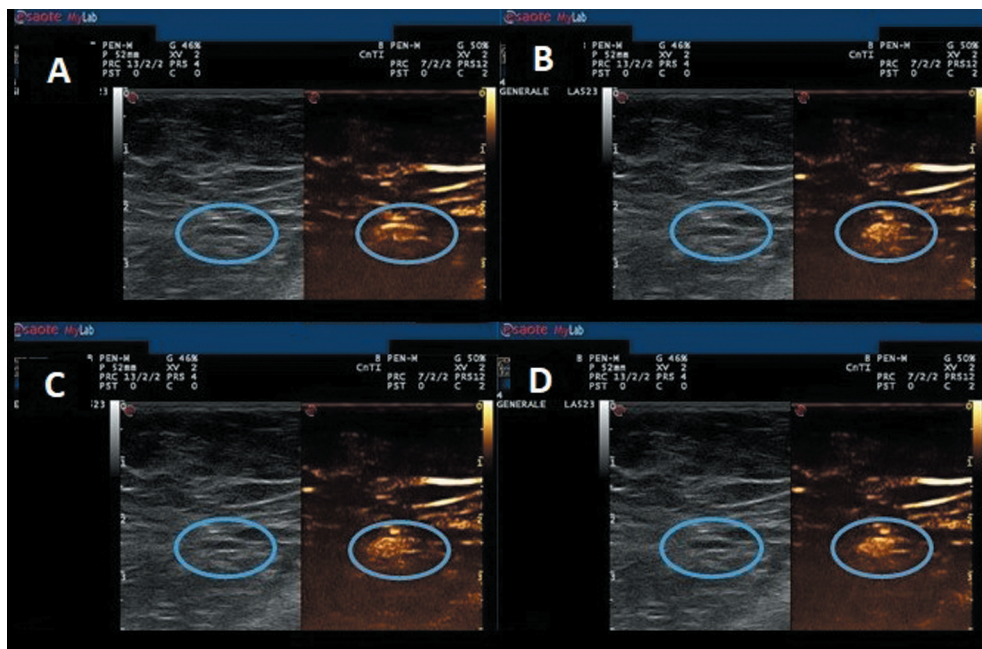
Axillary node enhanced in contrast-enhanced ultrasound (blue circle) at 15 (A), 25 (B), 35 (C) and 45 (D) seconds after 0.2 ml injection of Intradermal microbubble sulfur hexafluoride in the periareolar space.
